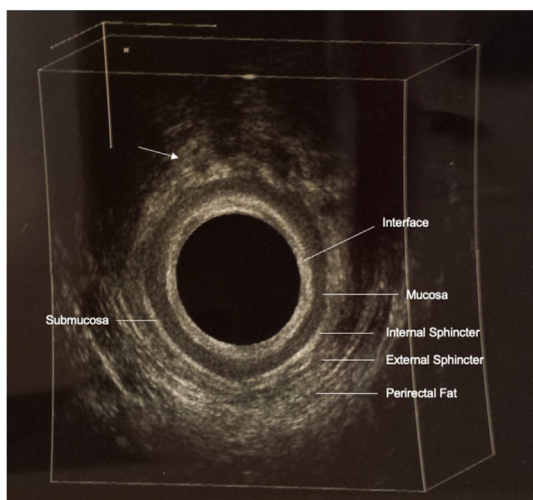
Endoanal ultrasound (EAUS) image showing a perianal mass at 11 o'clock sparing the anal sphincters.
